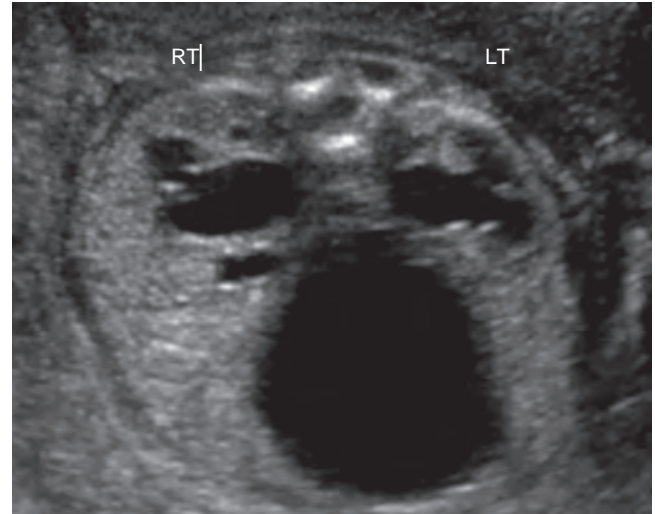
Antenatal ultrasound examination demonstrates bilateral severe pelvocaliectasis with dilated bladder in fetus. LT, left kidney; RT, right kidney. (Courtesy Dr. Mark P. Johnson, Children’s Hospital of Philadelphia.)
